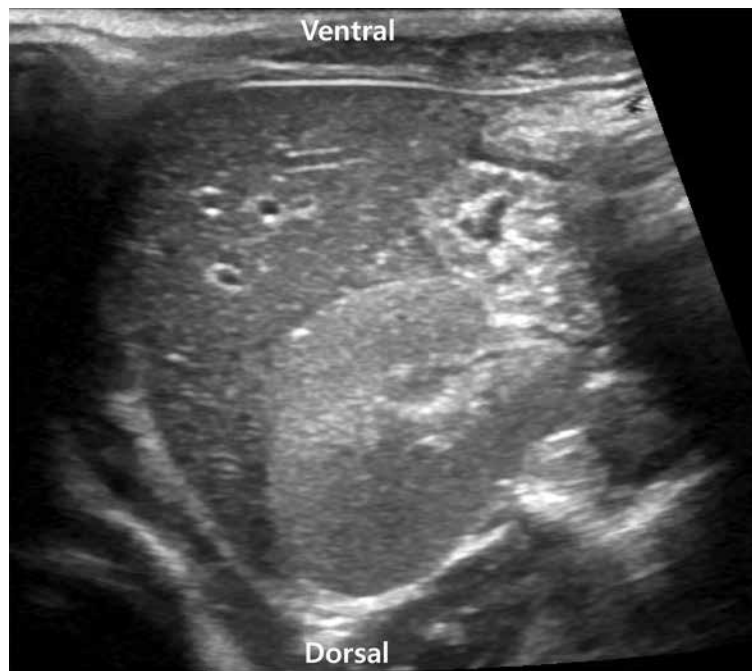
(A) To measure the diameter of vessels, the ultrasound transducer was placed perpendicular to the hepatic pedicle, and the echogenicity of the liver parenchyma was compared with that of kidney. (B) To measure the velocity within vessels, the ultrasound transducer was placed parallel with the hepatic pedicle.
